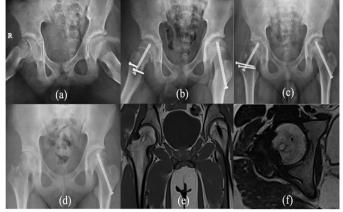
A 13-year-old male presented with acute unstable slip. (a) Pre-operative slip angle was 44. There was bleeding from the femoral head after drilling pre- and post-epiphyseal reduction. (b) Post-operative radiograph following right Extended Dunn Procedure and left in situ pinning. (c) 6 months after surgery, radiograph revealed rounded head with no necrosis of the femoral head. (d) Removal of implants was performed one year after Extended Dunn procedure. (e, f) 16 months post-operative MRI revealed a round femoral head with no avascular necrosis.
